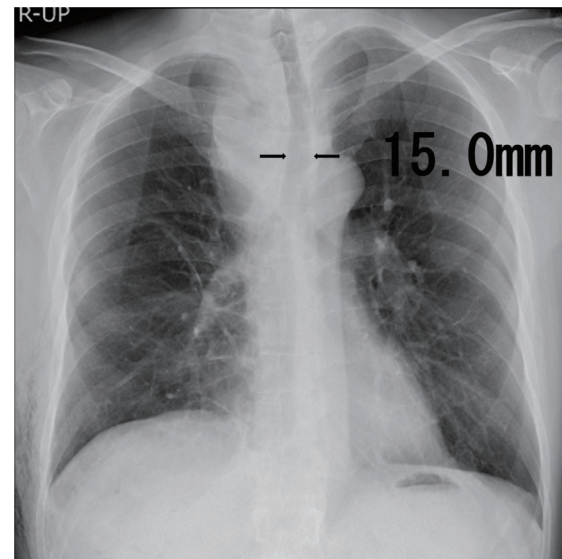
Radiograph 1 day after the operation, standing position.
